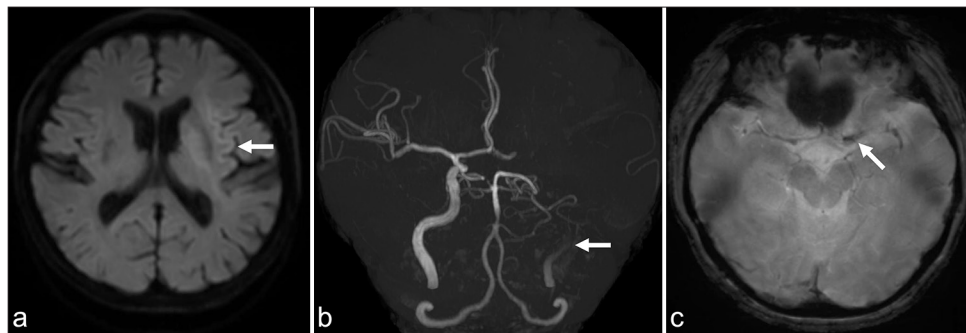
(a) Magnetic resonance imaging on admission showing infarcts in the left putamen and insular cortex (arrow). (b) Magnetic resonance angiography showing left internal carotid artery occlusion (arrow). (c) T2 star-weighted imaging showing the susceptibility vessel sign from the C1 segment of the left internal carotid artery to the proximal M1 segment of the left middle cerebral artery (arrow).
